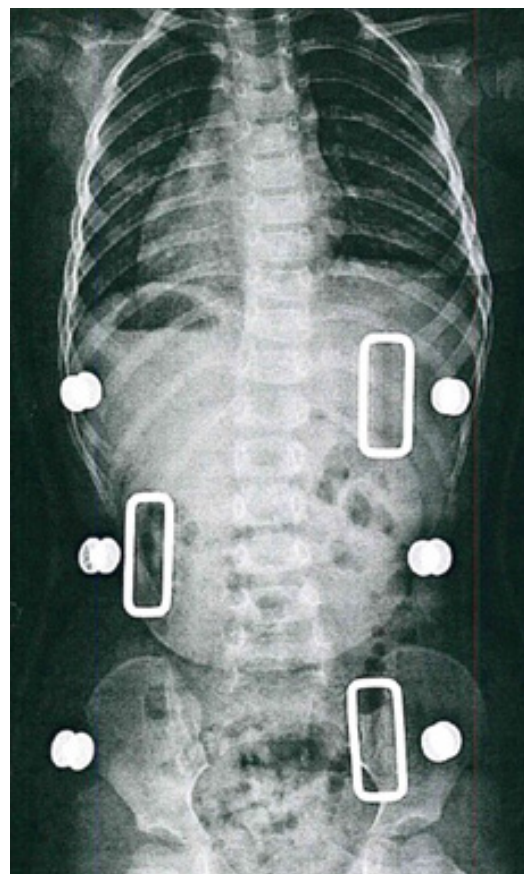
AP X-Ray Before Removing Final Brace
